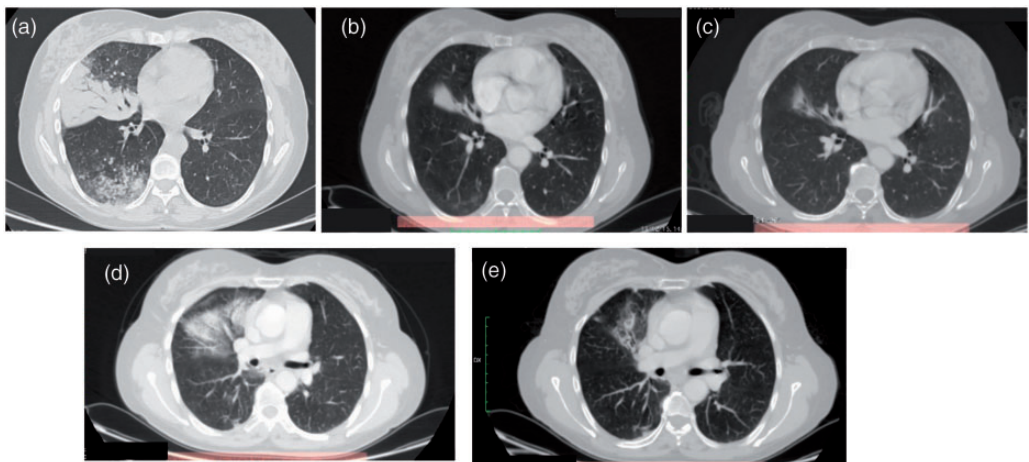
Computed tomography (CT) imaging (a) at diagnosis, (b) 3 months after treatment with 40 mg afatinib daily, (c) 13 months after dose reduction to 30 mg afatinib daily, (d) 1 month after radiotherapy, and (e) 8 months after radiotherapy.
